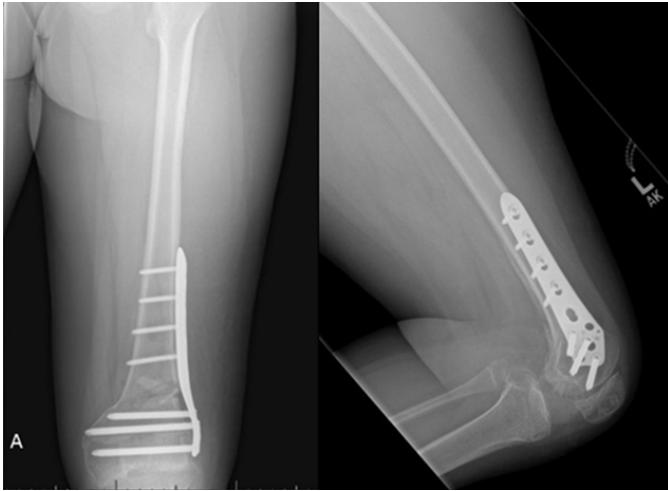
AP and lateral radiograph of the left knee 2 weeks after osteotomy.
